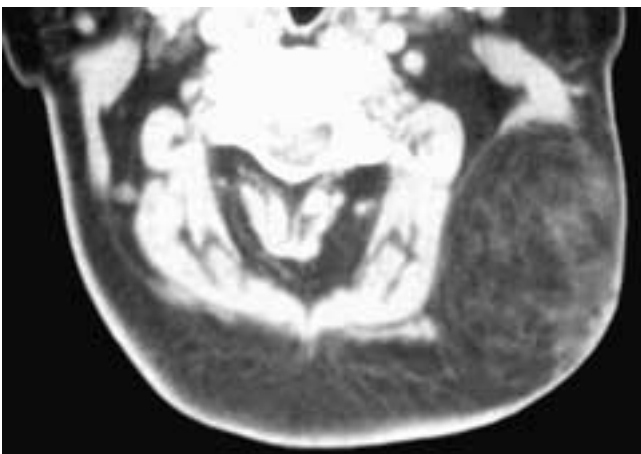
Axial contrast-enhanced CT scan shows a nonhomogeneous but primarily fatty mass in the posterior left neck. Portions of the lesion contour are well defined; others are poorly seen. This patient had a liposarcoma.
